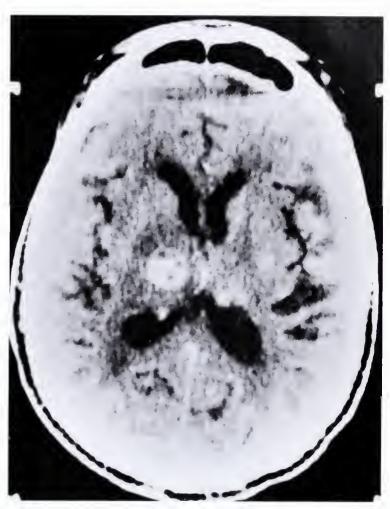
Contrast CT scan shows a rounded nonhomogeneously enhancing lesion in right thalamus with surrounding low density consistent with edema.
